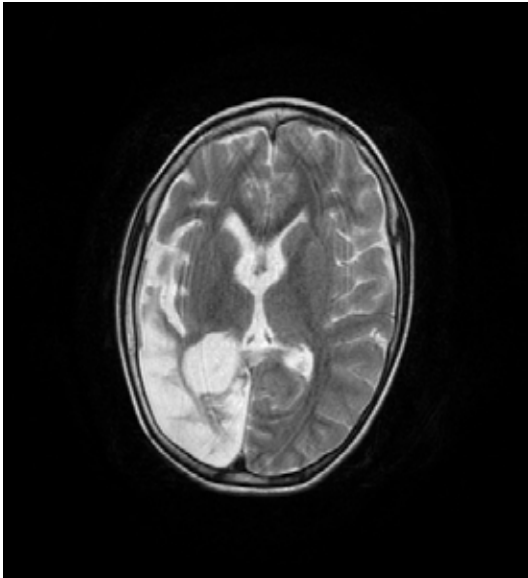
Axial T2W MRI brain reveals increased signal intensity in right insular cortex and temporo-parieto-occipital regions with dilated ipsilateral lateral ventricle with prominent adjacent sulcal spaces.
